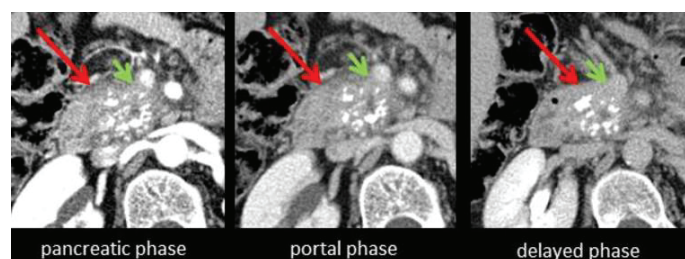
CT images - Focal chronic pancreatitis
